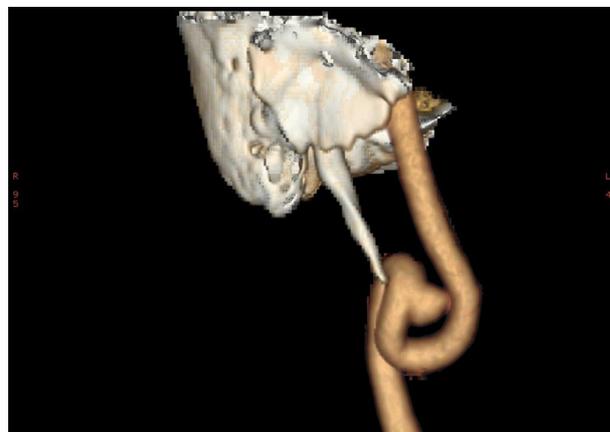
CT-angiography with 3D reconstruction showing impingement between styloid process and internal carotid artery (carotid dissection) in stylohyoid syndrome (from Karam C, Koussa S. Eagle syndrome: the role of CT scan with 3D reconstructions. *J Neuroradiol* 2007;34:344–345).
